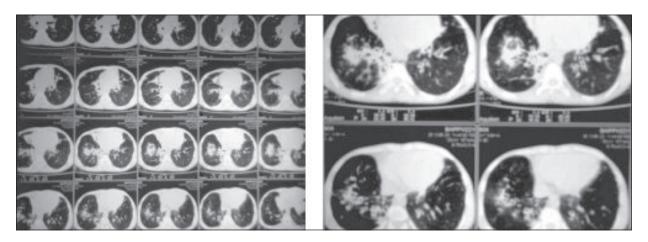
HRCT* scan of chest showing, bilateral traction bronchiectasis, consolidation in right upper lobe and collapsed middle lobe.
